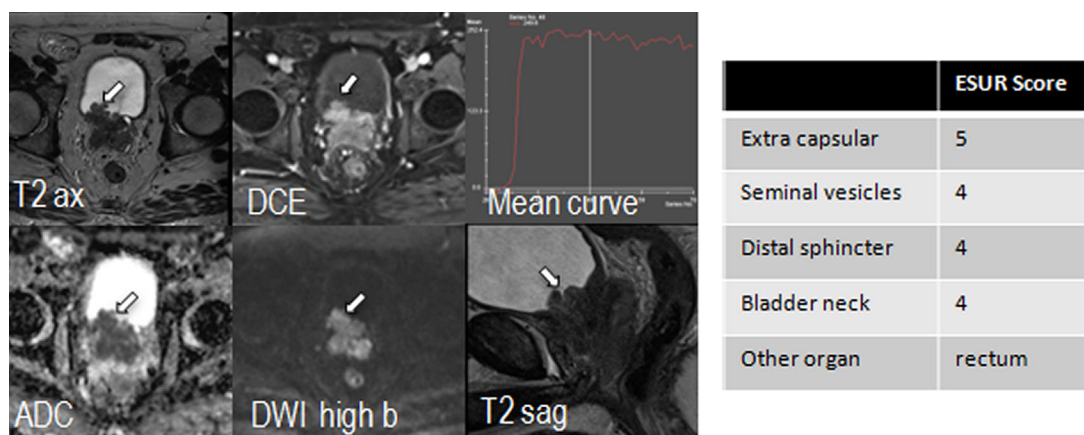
Example of multiparametric (mpMRI) T staging: tumor diffusely infiltrates the prostate, showing low signal intensity on T2 images, high signal intensity on DWI with low ADC values, type 3 enhancement curve. There is non-ambiguous extension to the bladder wall (arrows) and other organs (extraprostatic spread scored 17 according to ESUR criteria).
